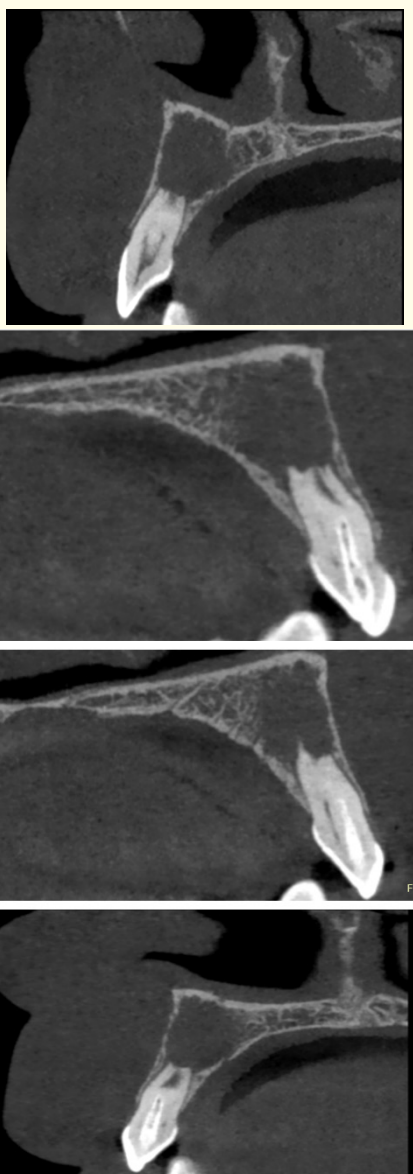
CBCT sagittal slices showing Type IIIb invagination and periapical lesion.
